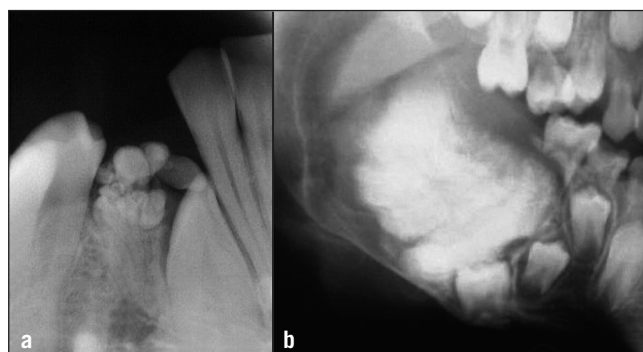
Comparison of radiographs showing complex (a) and compound (b) odontomas.
